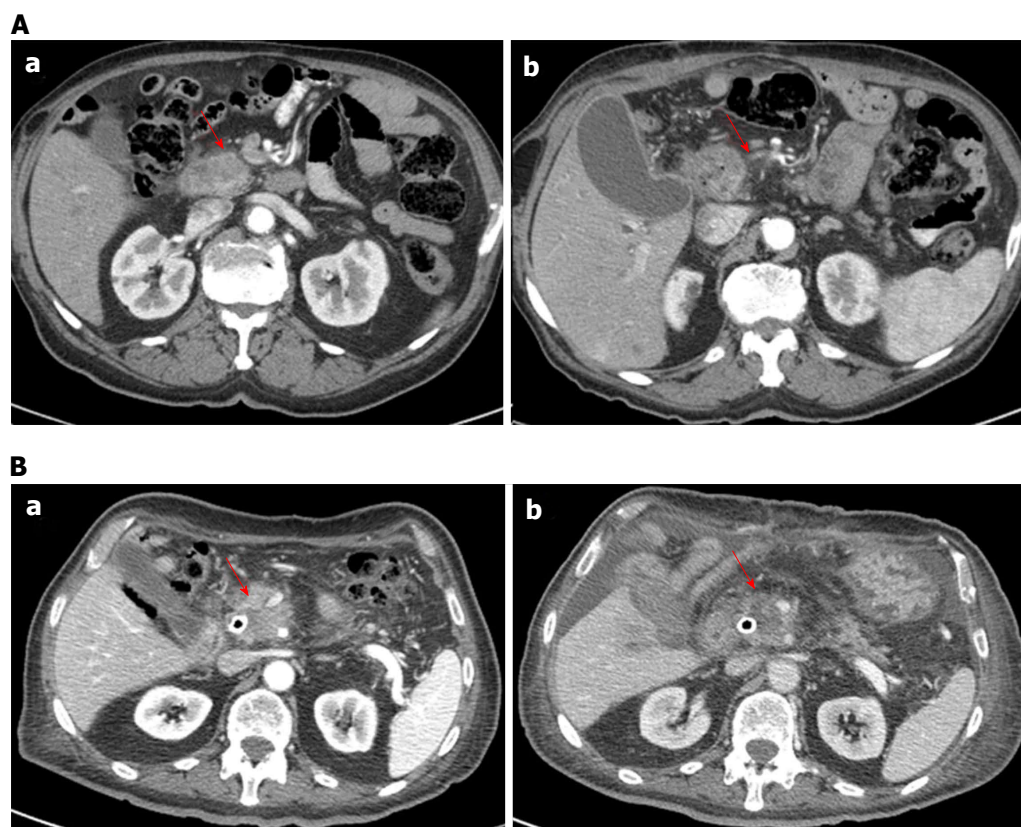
Computed tomography imaging assessment using morphological criteria for two patients (in A man 79 years old and in B man 74 years old). In pancreatic phase on CT study (a) the lesion appears hypodense (arrow). After the treatment in pancreatic phase on CT study (b) the lesion appears similar than in (a) but there was a significant variation in CT density value. CT: Computed tomography.
